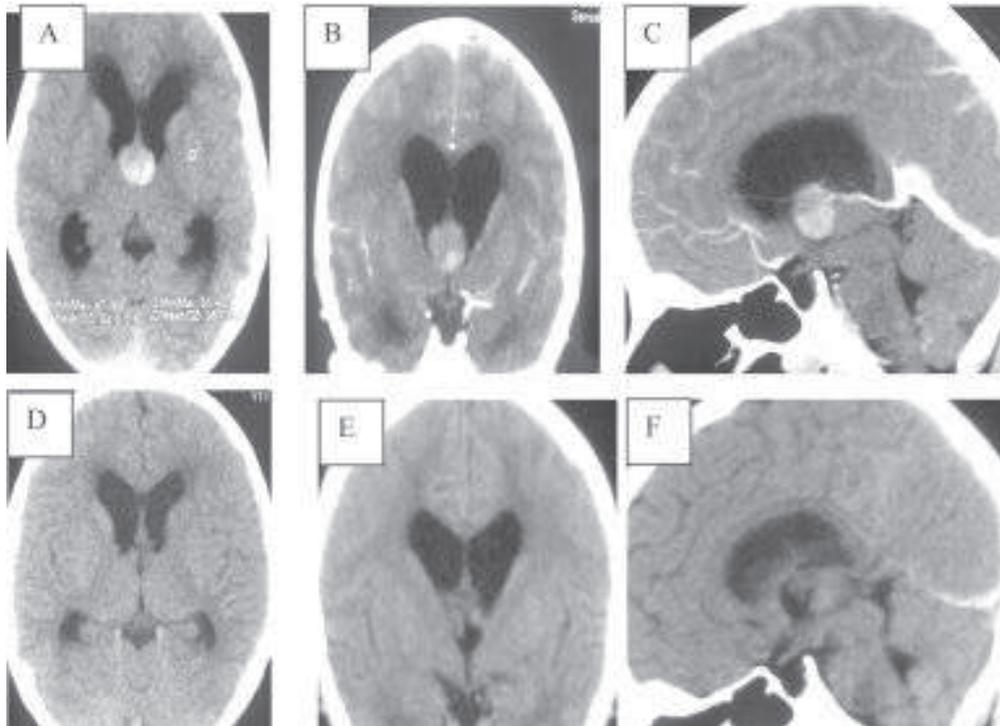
Preoperative and postoperative CT imaging of the patient, A,B, C, revealed axial, coronal and sagittal CT scan shows hyperdense mass in the anterior 3rd ventricle. D, E, F, Postoperative CT shows no residual colloid cyst and establishment of CSF pathway.
